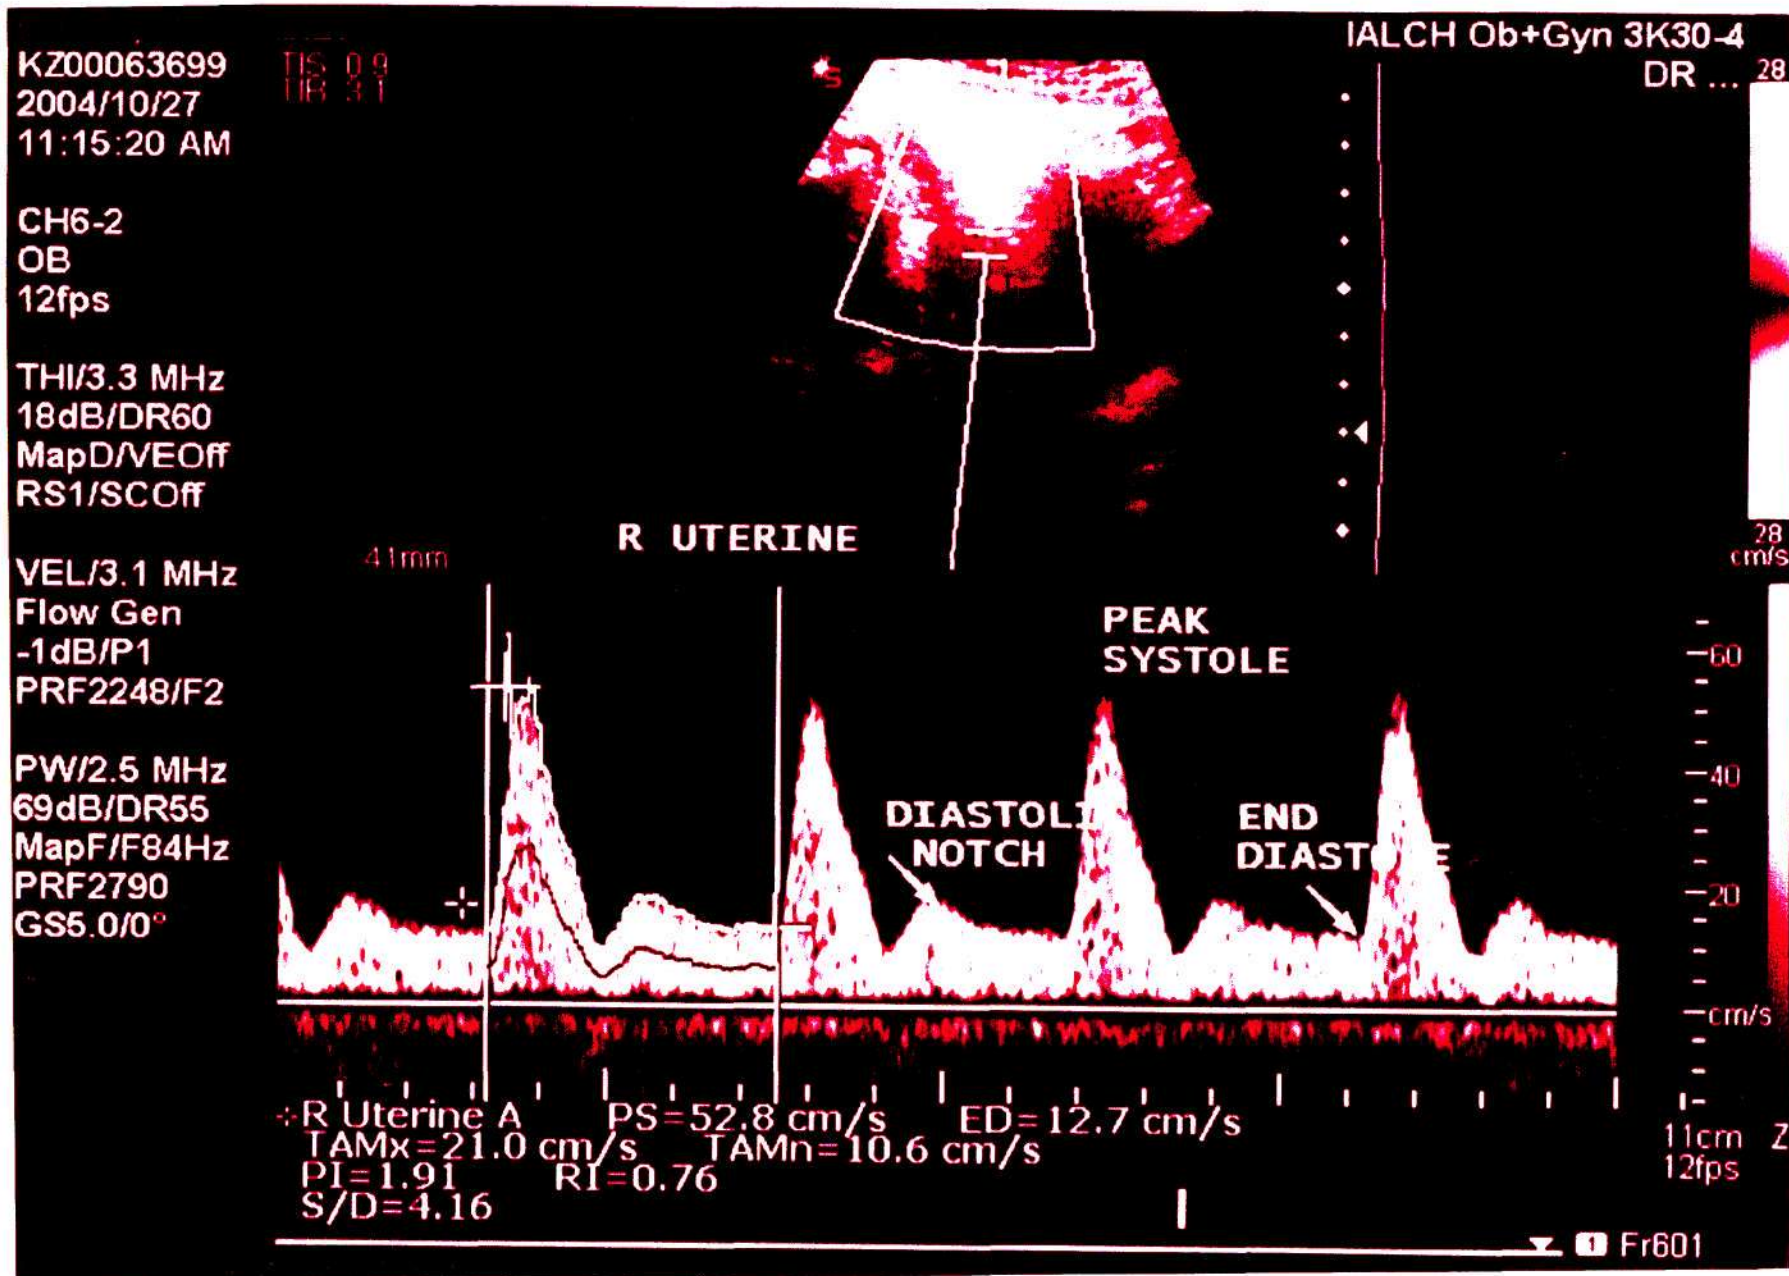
(b) - Uterine artery Doppler velocimetry (Pre-Eclampsia)
